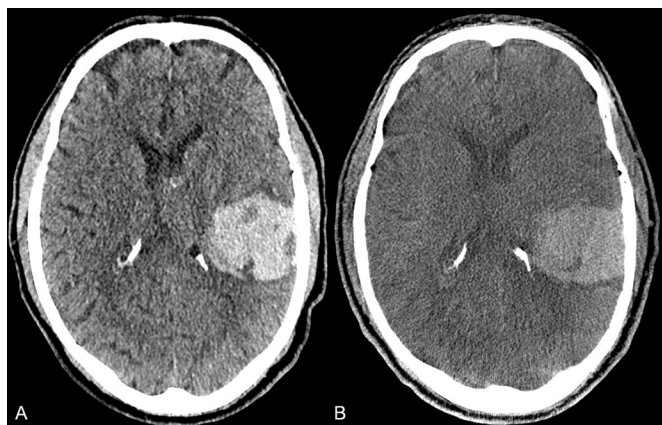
Axial images from a patient with an intraparenchymal hemorrhage of the left parietotemporal lobe in MDCT (A) and follow-up FDCT (B) in the angiography suite prior to conventional angiography to rule out a vascular pathology for the hemorrhage. The margins of the hemorrhage and the perifocal edema are well delineated in the FDCT image. FDCT, flat detector computed tomography; MDCT, multidetector computed tomography.
